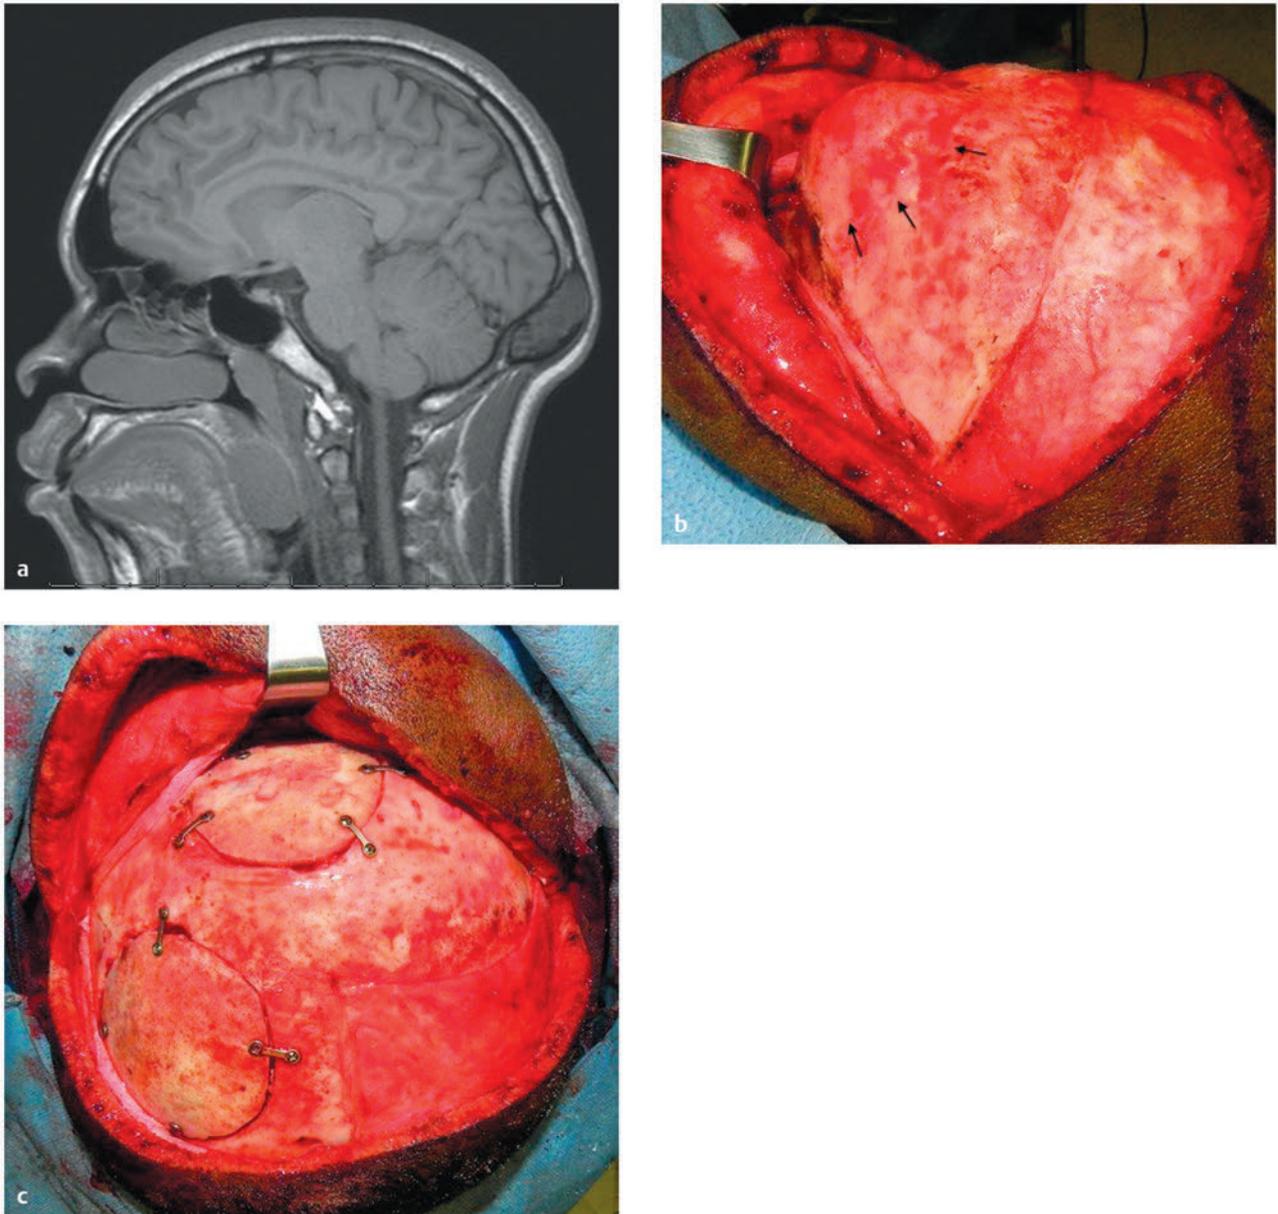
Fibrous dysplasia. This 17-year-old young man presented with a long-standing occipital mass that had recently enlarged and became tender. (a) Sagittal T1-weighted magnetic resonance image showing isointense expansile calvarial lesion in the region of the inion. (b) Intraoperative photograph of lesion. (c) Intraoperative photograph showing reconstruction with split-thickness autologous cranial bone.
